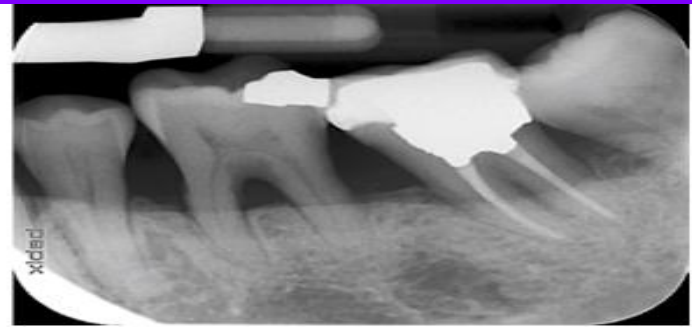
Various stages of furcation involvement as depicted on periapical images. (a) The radiograph shows a slight radiolucency in the most coronal aspect of the furcation of tooth 46. (b) This periapical radiograph shows radiolucency in the furcation of tooth 36 that reaches the middle-third of the root. Different crestal bone levels may mimic no radiolucency in the furcation of tooth 37. (c) This radiograph exhibits a radiolucency of the furcation of tooth 26 that extends up to the apex of the respective roots.
